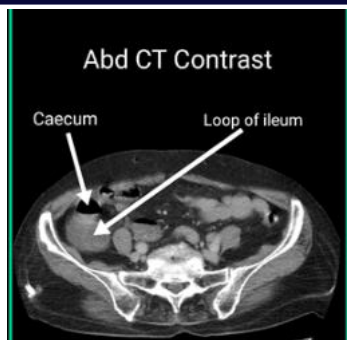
Computed Tomography (Contrast) of abdomen showing retro-cecal herniation.
